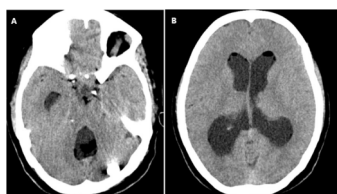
Axial non contrast CT: a) Mixed fat and soft tissue dense lesion in fourth ventricle. A well defined calcific lesion (HU 400-600) with broad base towards dura noted along left occipital bone. b) Fat densities noted in non dependent position (fat fluid level, HU (-40 to -80)) of frontal horns of bilateral lateral ventricles.
